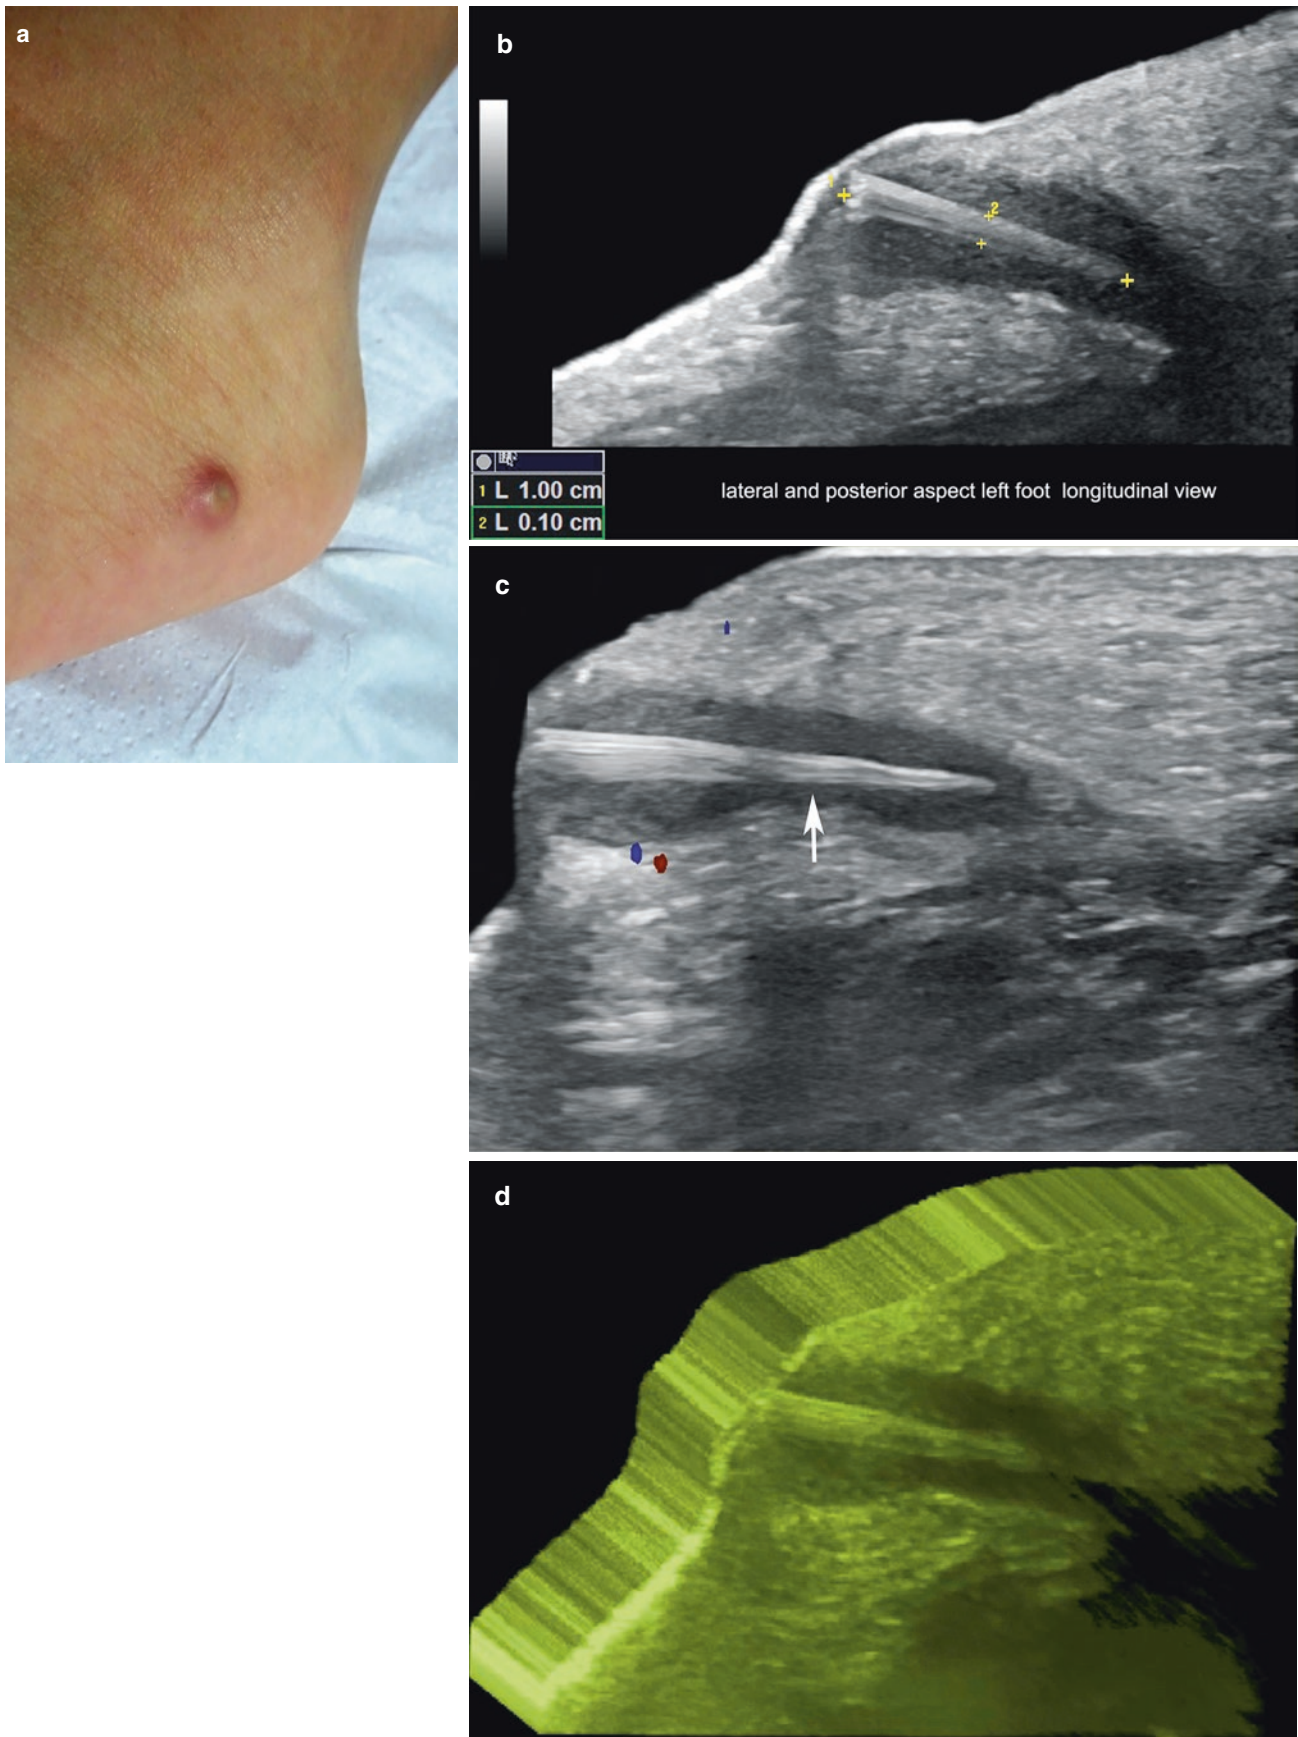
Splinter of wood. (a) Clinical image of the lesion. (b–d) Ultrasound (b, greyscale; c, color Doppler; d, 3D reconstruction; longitudinal and posterior aspect of the left foot) demonstrates 1.0 cm long \times 0.1 cm thick, dermal and hypodermal hyperechoic linear structure (between markers in b) surrounded by hypoechoic tissue (arrow in c). There is a slight increase of vascularity in the periphery of the lesion.
